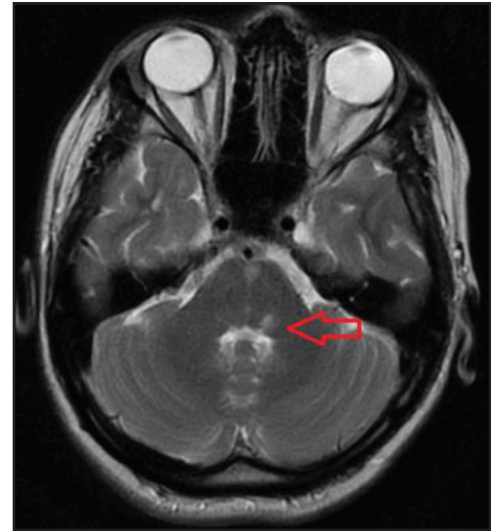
MRI brain with contrast (T2W) showing two well defined round hyperintense lesions along the midline of pons and left middle cerebellar peduncle
